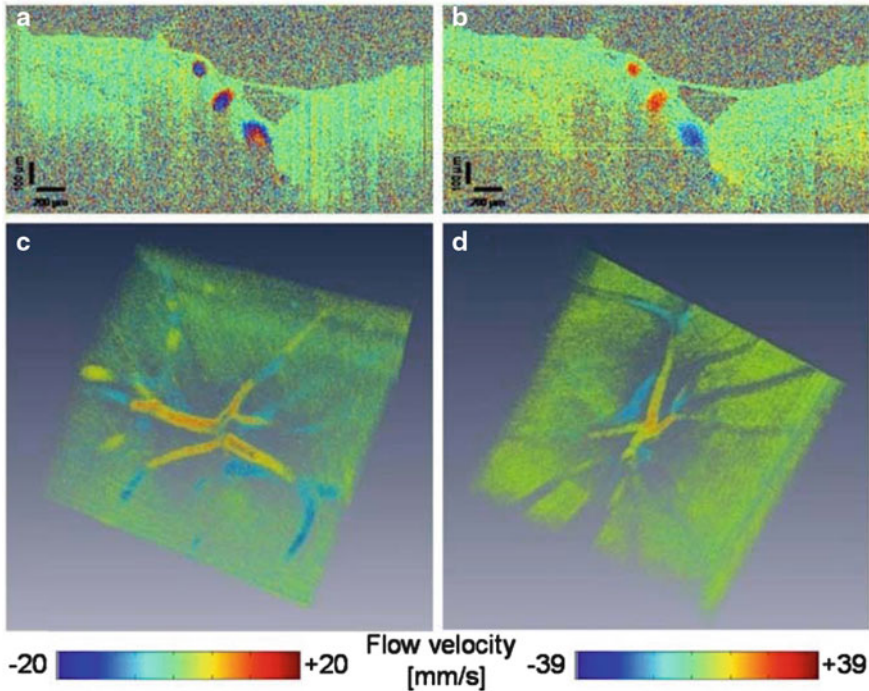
Volumetric Doppler OCT imaging of retinal vasculature. (a and b) B-scan images close to the optic disk at 100 kHz and 200 kHz, respectively. (c and d) volumetric images of the retinal arteries and veins branching in the optic disk at 100 and 200 kHz
